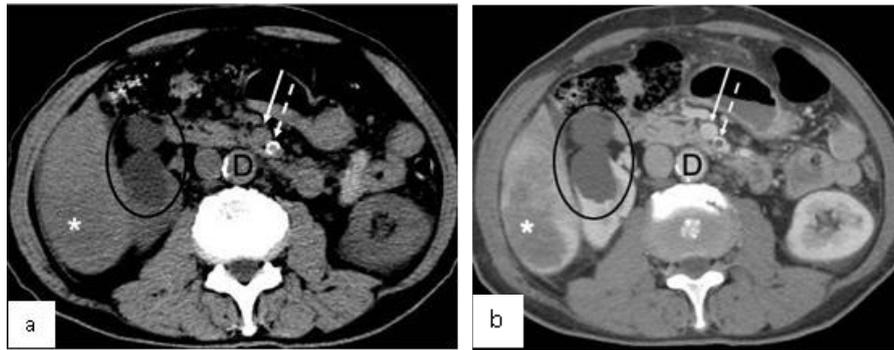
Non-contrast (a) and contrast-enhanced (b) CT images of the abdomen of a 71-year-old male with a history of colon cancer shows ill-defined heterogeneously enhancing low density areas in the liver (white asterisk) consistent with hepatic metastasis. The well-defined non-enhancing hypodense area in the upper pole of the right kidney (black circle) is consistent with a simple renal cyst. Solid and dashed white arrows point to the SMV and SMA, respectively. Note calcification of the wall of the abdominal aorta (D) and SMA (dashed white arrow). The absence of contrast in the SMA in the contrast-enhanced image (b) is described radiologically as a filling defect and suggests the presence of a thrombus. Comparison with Figure 8 will help in appreciating the filling defect in the SMA
